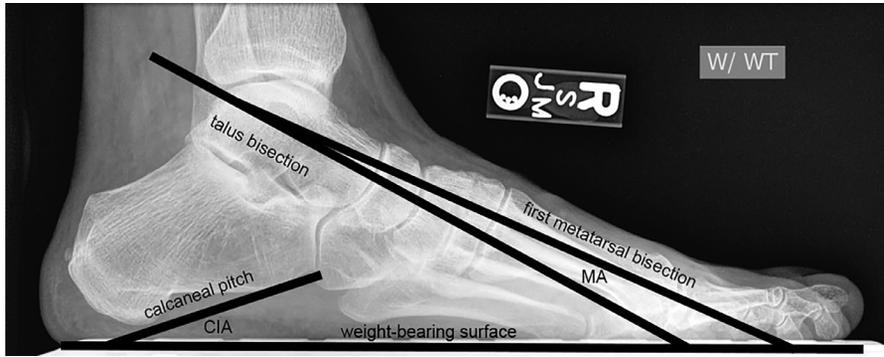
Radiographic angles measured in the lateral projection radiograph.
